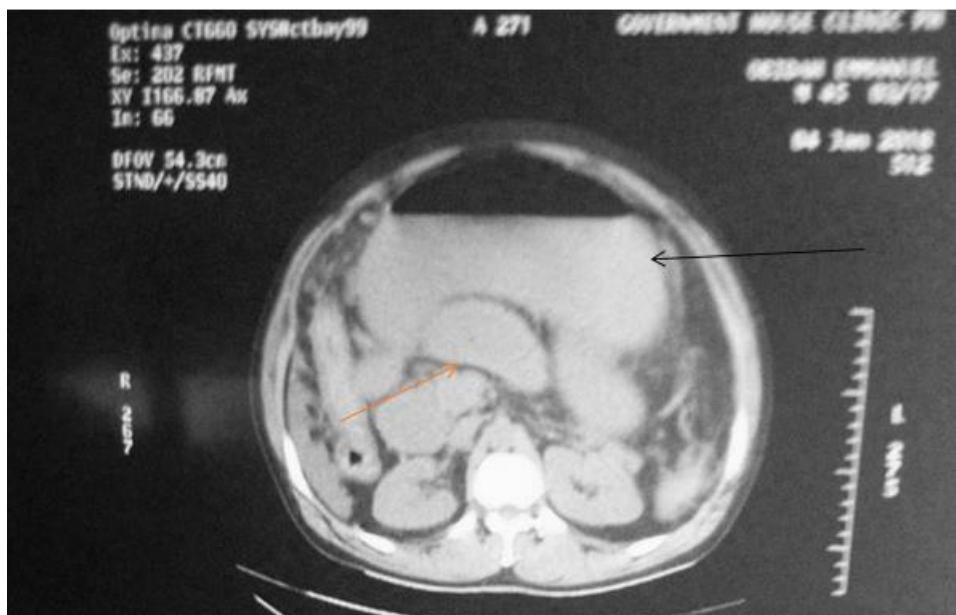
Non contrast enhanced axial CT of the abdomen showing a dilated stomach (Black arrow) and proximal small bowel (Red arrow)
